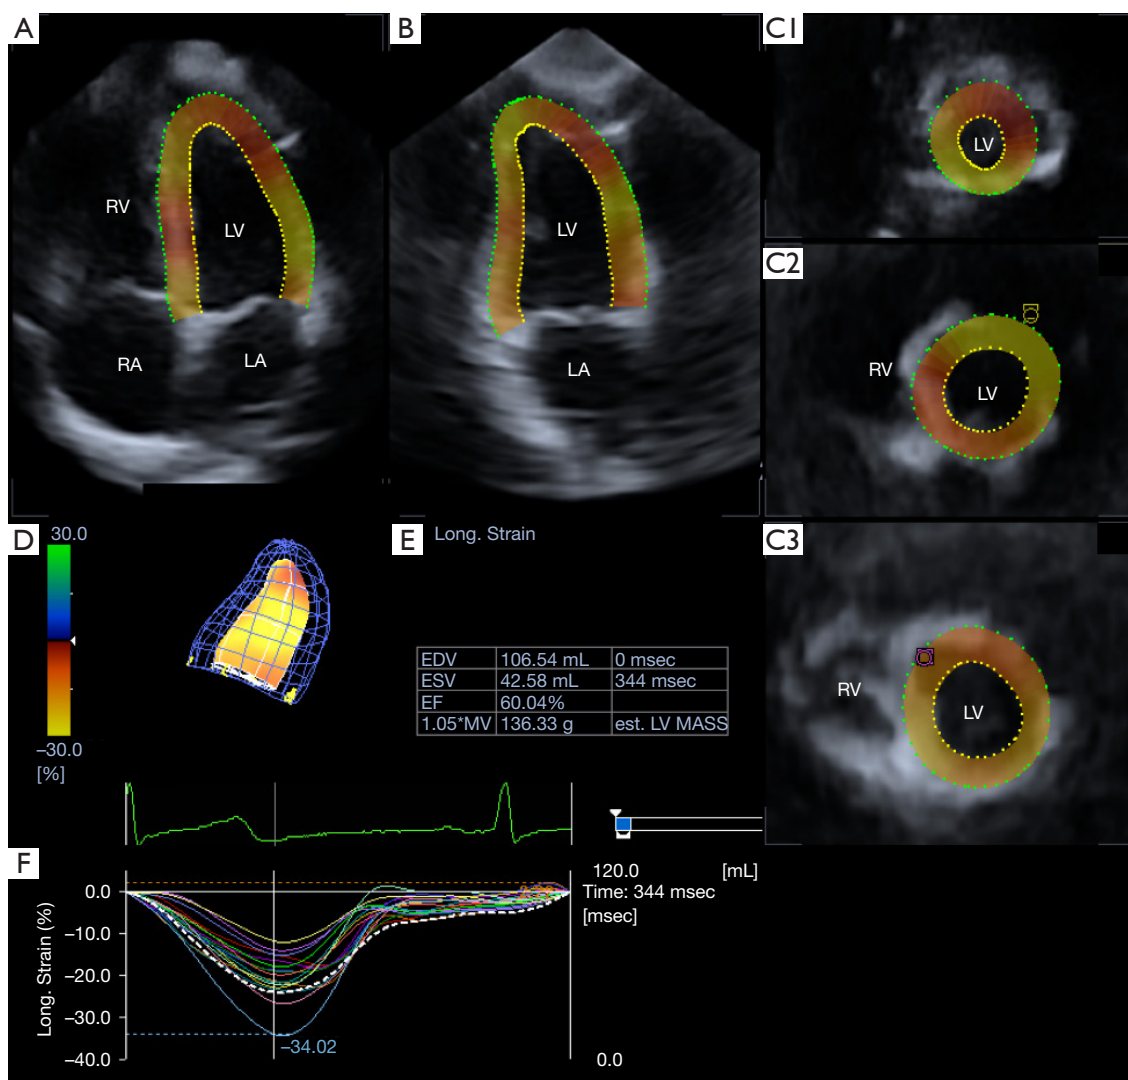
The apical four- (A) and two-chamber (B) views and 3 short-axis views at different left ventricular (LV) levels (C1, C2, C3) are presented in a healthy case. The three-dimensional LV cast (D) together with LV volumetric data (E) and LV segmental longitudinal strains (coloured lines) and LV volume-change (dashed line) regarding the cardiac cycle (F) are also presented. LA, left atrium; LV, left ventricle; RA, right atrium; RV, right ventricle.
